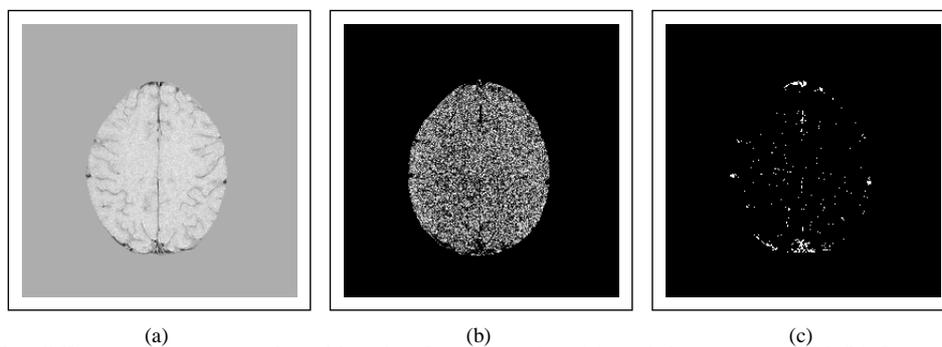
The difference images produced by simple subtraction (a) and the new method (b) from the MRI brain scans of an MS patient, and the result of thresholding the image at the 1% level (c).
